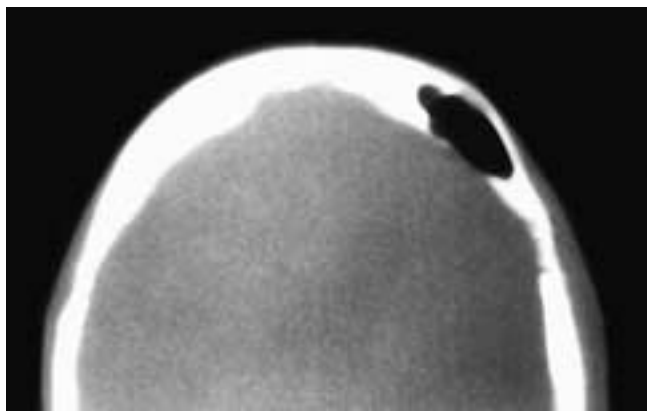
Axial CT scan shows the upper region of a large left frontal sinus with normal mucosa. A portion of the posterior sinus wall is thinned. This patient had a pneumocele.
